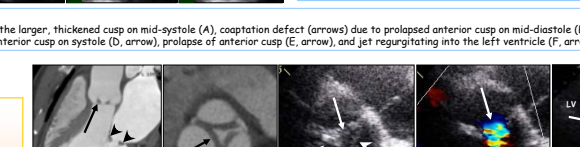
Bicuspid aortic valve with AR in a 47-year-old man. Multiplanar reformatted CT images (A, B) - Upcoming of thickened and partially calcified cusps of bicuspid aortic valve (arrows), dilated aortic root, and dilated left ventricle on mid-systole (A, B). Large coaptation defect (arrows) due to prolapsed cusps and dilated aortic root on mid-diastole (C, D). Echocardiographic images (E-F) - Bicuspid AV with heavy calcification of anterior leaflet (E, arrow) and moderate or severe AR due to incomplete coaptation (F, arrow) and a jet regurgitating into the left ventricle during diastole (G, arrow).
